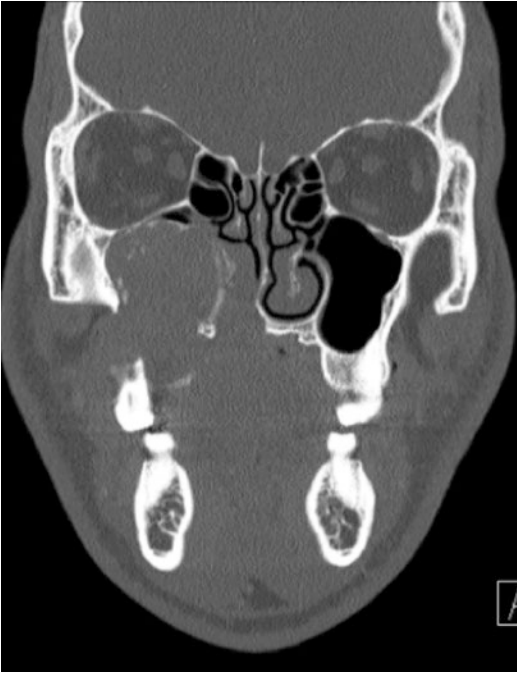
Bone window CT, coronal cut for case #2. (Courtesy of Dr. Fayette Williams)
